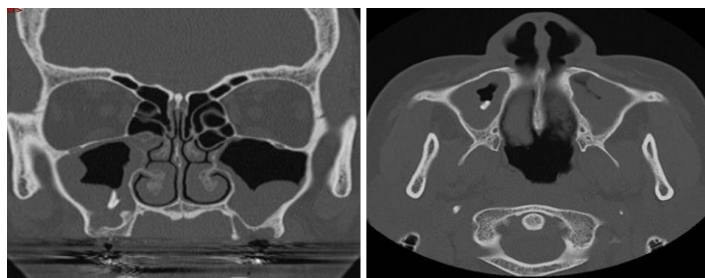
CT shows tooth root in the maxillary sinus
